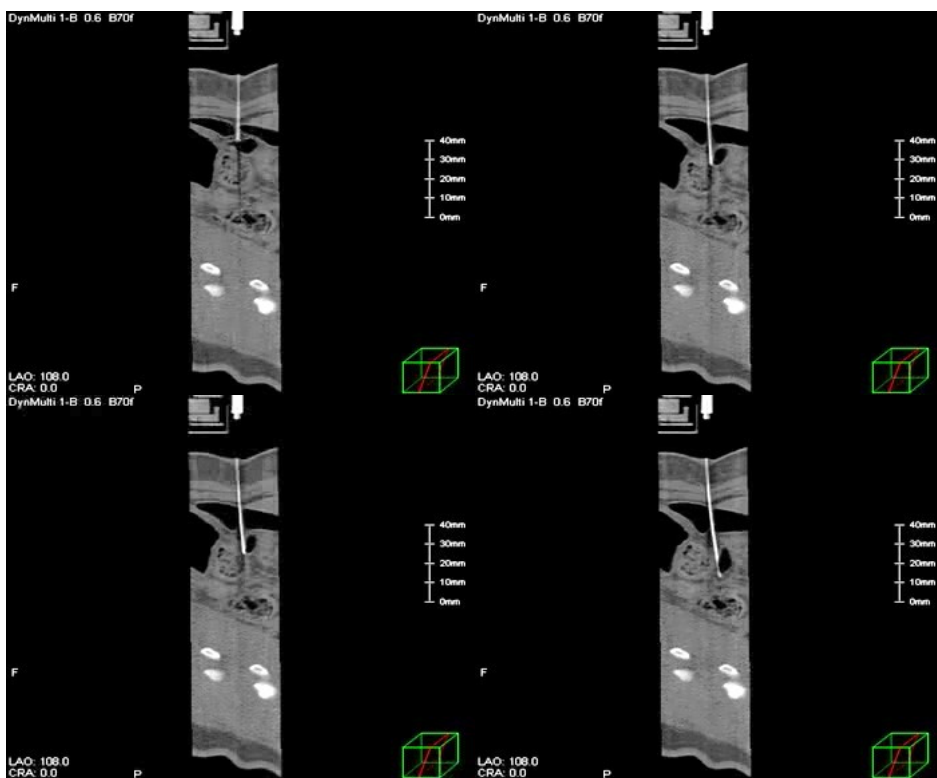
The sequential sagittal CT images tracking the needle in No. 1 insertion path
